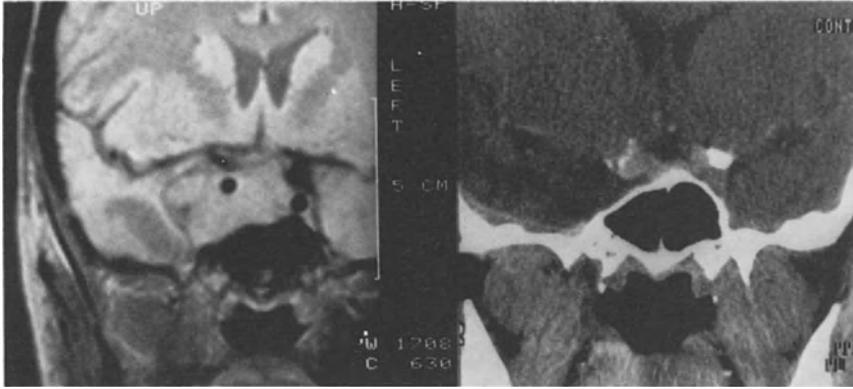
Nuclear magnetic resonance image of intracavernous meningioma with tumor invasion into the hypophyseal region and suprasellar extension. Notice intracavernous ICA surrounded by tumor tissue 3 years after subtotal tumor removal via the subtemporal lateral approach and radiosurgery of residual intracavernous tumor 1 year later. Postoperative contrast CCT scan in coronary sections 4 weeks after the Dolenc approach demonstrates total removal of the tumor with preservation of the ICA and the IIIrd cranial nerves
